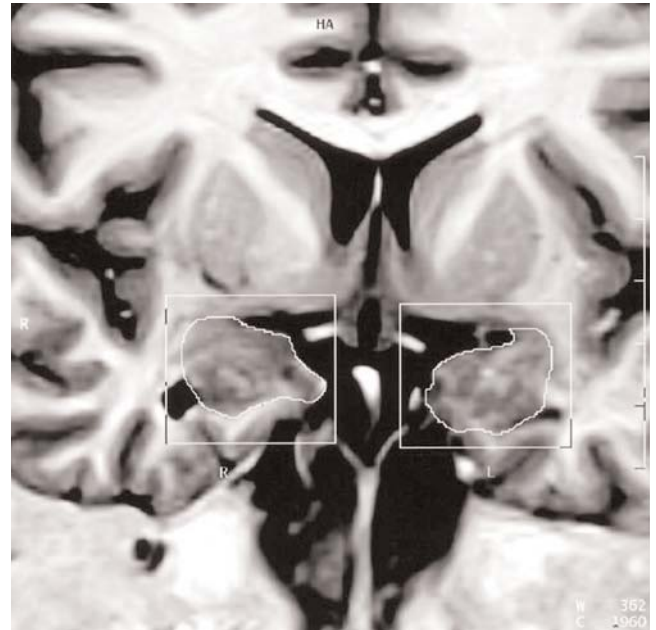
Amygdaloid body area measurement. From "Morphometry of some elements of limbic system in normal population: a quantitative MRI study" by Yücel K, Hakyemez B, Parlak M, Oygucu IH. Neuroanatomy 2002;1:15–21.^[33] © neuroanatomy.org. Reprinted with permission.
